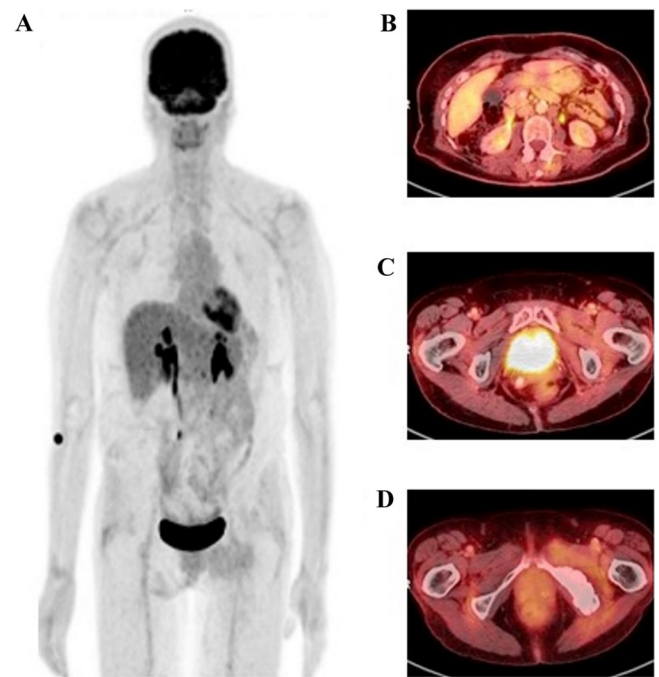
$^{18}\text{F}$ -FDG-PET/CT and efficacy of treatment (December 2019). (A) PET scan and co-registered PET/CT scan with low FDG uptake in (B) remaining paraaortic lymph node, and no evidence of pathologic FDG uptake in (C) uterus stump and (D) left ischium. F-FDG, 2-deoxy-2-[fluorine-18]fluoro-D-glucose; PET, positron emission tomography; CT, computed tomography.
